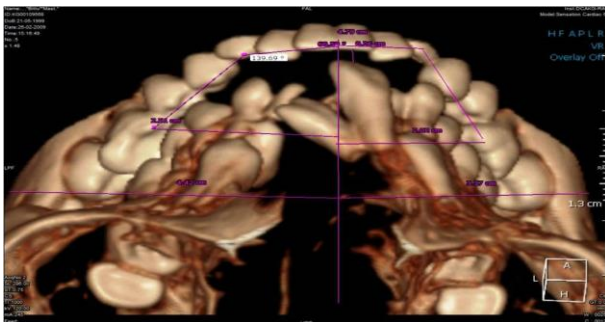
CT scan (Occlusal view).
